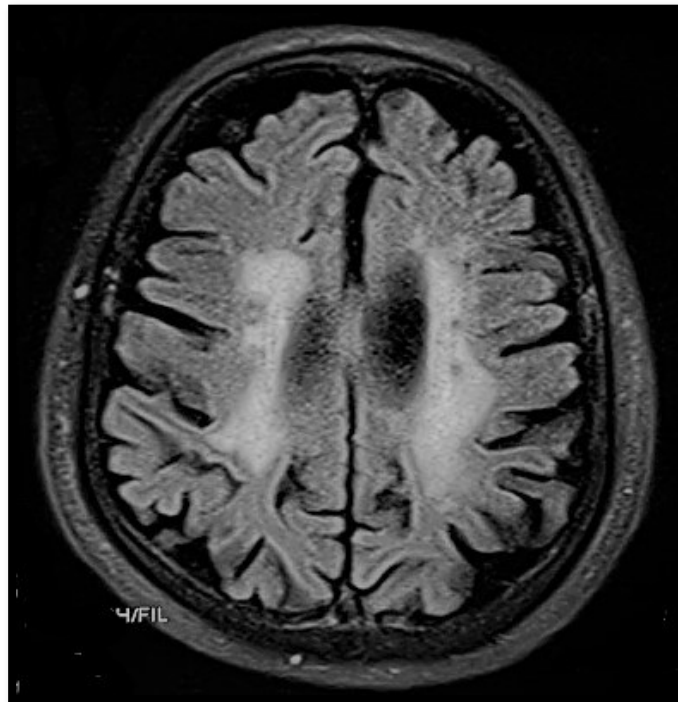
Generalized brain atrophy in MRI
